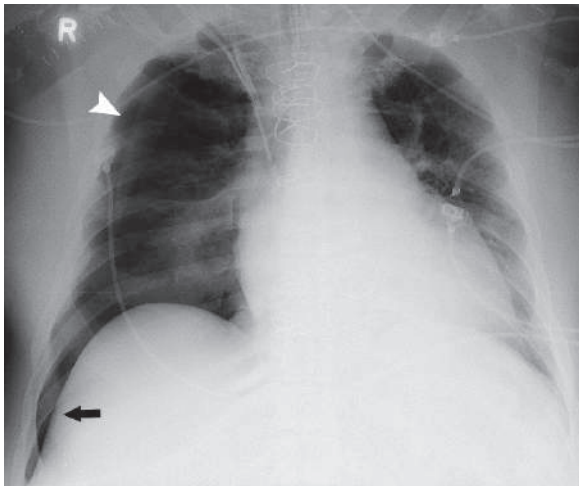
Posteroanterior chest radiograph shows right-sided pneumothorax (*arrowhead*) with right deep sulcus sign (*arrow*)
